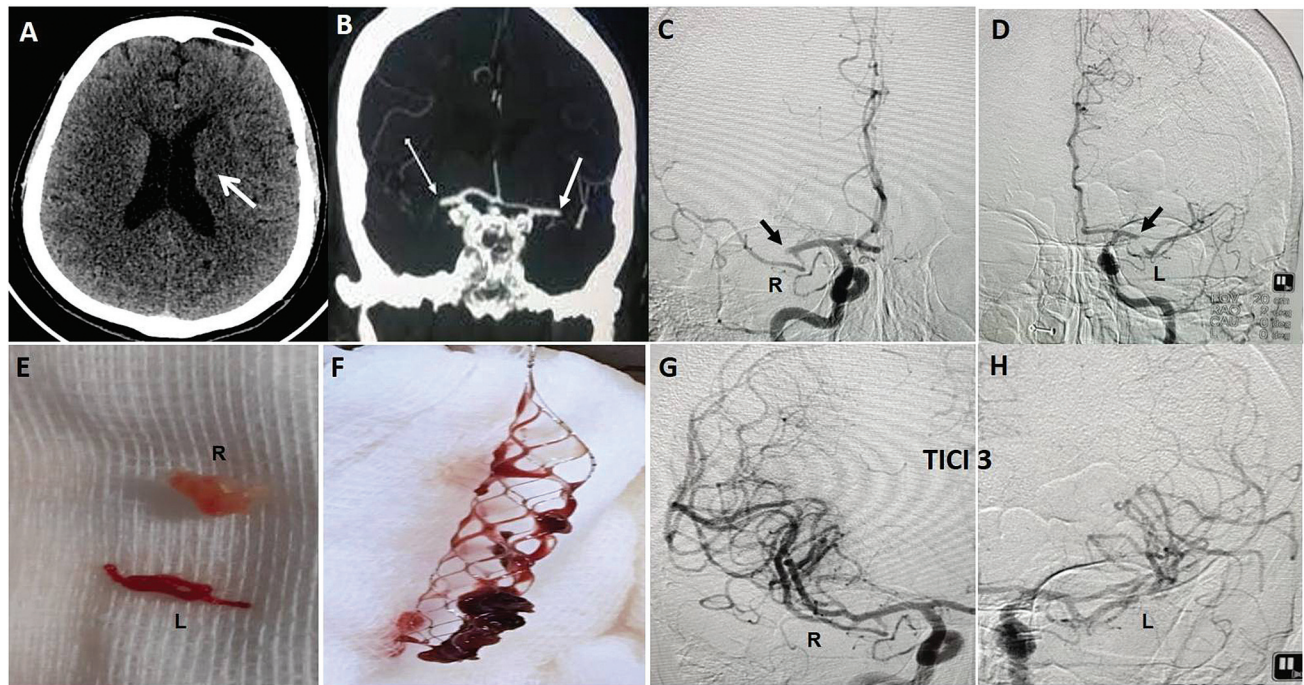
Plain computed tomography (CT) brain shows hyperacute infarct in left basal ganglia (arrow) with aspect score of 7/10 on left side and 10/10 on right side (A). CT angiogram and diagnostic digital subtraction angiogram show complete cutoff of M1 segment of bilateral middle cerebral arteries (arrows) (B–D). Mechanical thrombectomy using 6 × 20 stentriever retrieved fleshy firm tissue from both the middle cerebral arteries (E and F) resulting in treatment in cerebral infarction score 3 (TICI3) recanalization (G and H).
